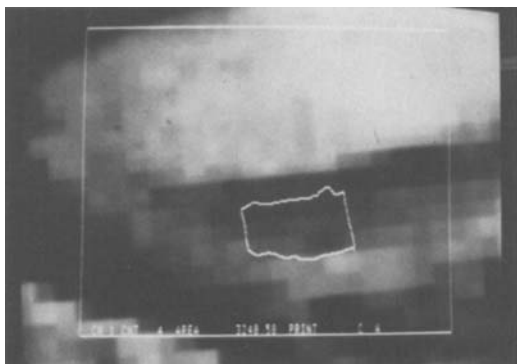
T1-weighted image (section) enlarged and projected on to the monitor. The cartilage area to be measured is outlined with the cursor.
